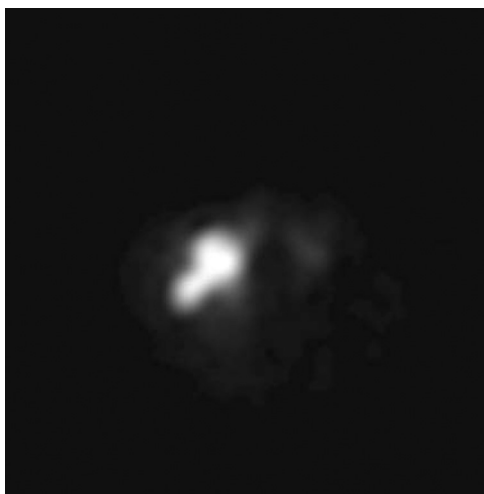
Representative axial SPECT image.
